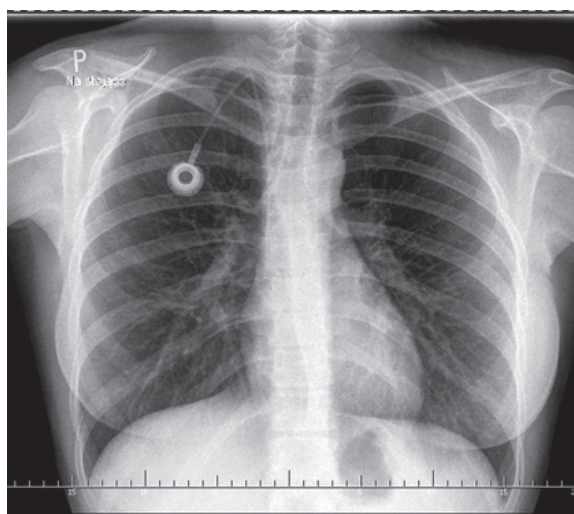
Location of venous access port in X-ray image (source: the patient's records)
